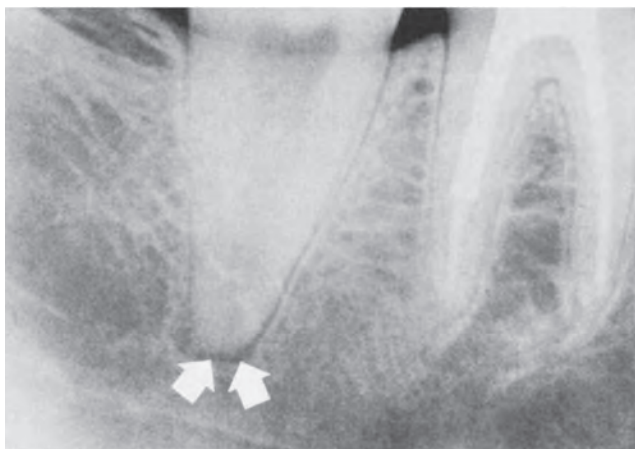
Radiographic features of symptomatic apical periodontitis. The periodontal ligament space is widened at the apex (*arrows*). Clinically, the tooth is exquisitely sensitive to percussion.
